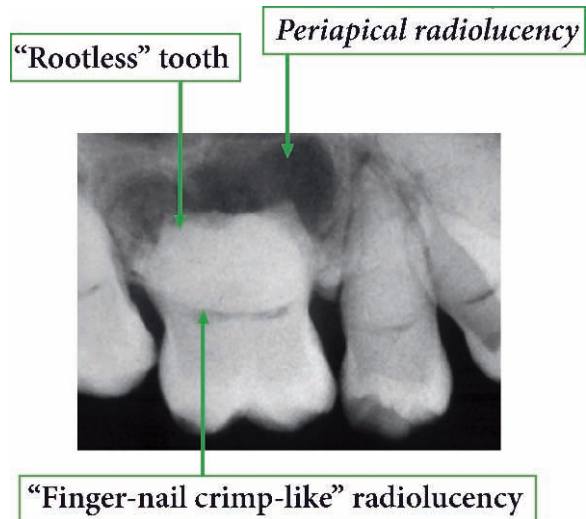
Radicular (Type I) dentin dysplasia. Note typical features of short blunt roots without noticeable pulp canals. Periapical radiolucencies are frequent. Maintenance of such teeth is usually not feasible
